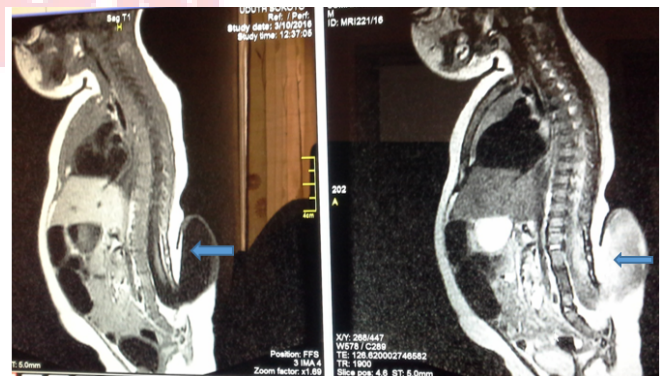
MRI images; sagittal views with T1 on the left and T2 on the right each showing a posteriorly located CSF filled sac like structure (left blue arrows) that seem continues with the spinal canal at the first sacral vertebral level. No spinal cord tissue is seen within this sac. This is a meningocele.
